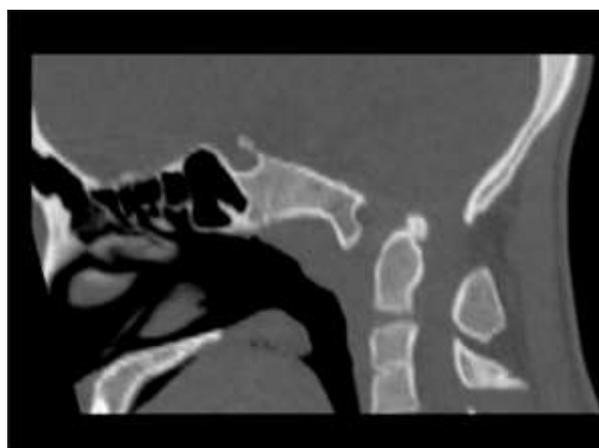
The T1W MRI images shows increase in anteroposterior diameter of preodontoid space (measuring 7 mm). There is an independent osseous structure located in distal end of clivus suggesting condylus tertius.
